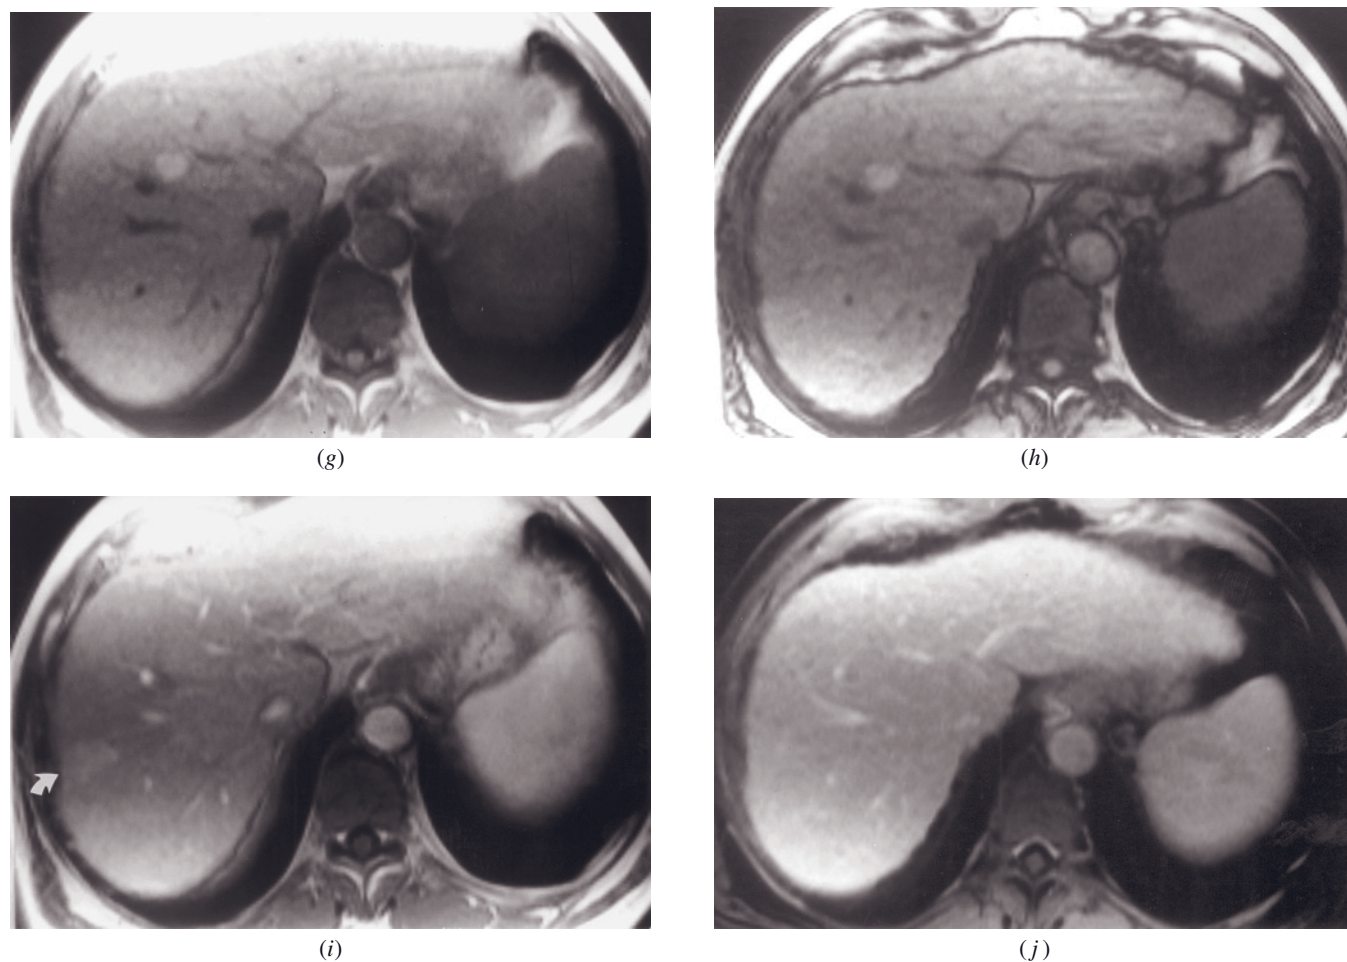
(Continued) signal on noncontrast T1-weighted (g) and out-of-phase (h) images. Lesions are not apparent on early (i) or late (j) postgadolinium images, consistent with regenerative or mildly dysplastic nodules. Note also the fine reticular pattern on postgadolinium images (i, j) with progressive enhancement, consistent with fibrotic change associated with cirrhosis. A small transiently enhancing focus (curved arrow, i) is present in segment 8, which reflects a focal hyperperfusion abnormality.
